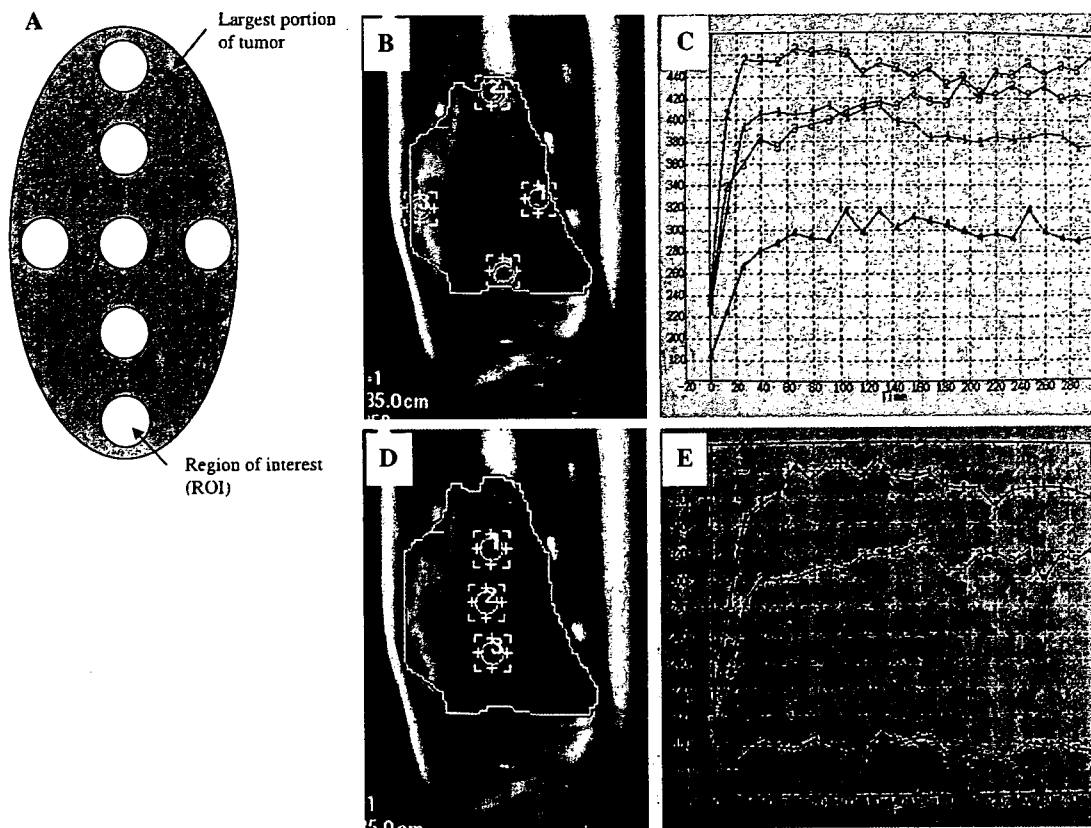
A large ROI and seven small ROI are set within the largest portion of the tumor (a: scheme of 7 ROI set within the tumor). Seven ROI placed on the dynamic contrast-enhanced MRI of osteosarcoma arising from the distal femur (b, d). Four ROI were placed evenly on
